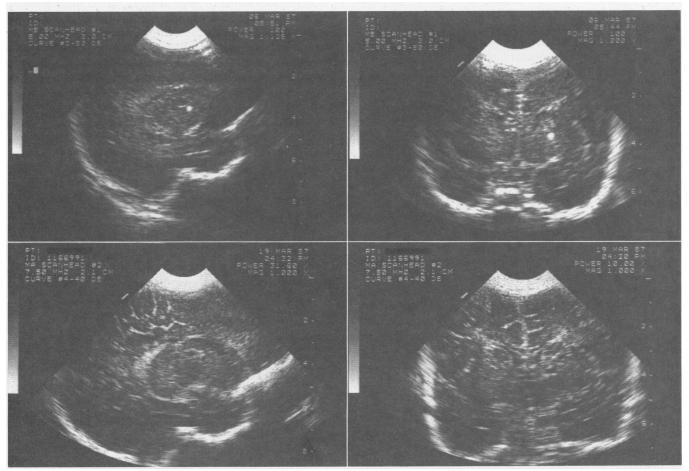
Upper left, A parasagittal cranial ultrasonogram on day 1 shows an area of hemorrhage (round white lesion) at the base of the brain.
